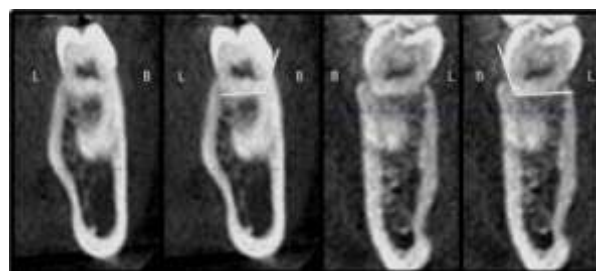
Crown furcation roof angle was measured cross-sectional CB-CT images at selected mandibular first molar teeth. Crown furcation roof angle, is the angle of the line drawn between the furcation entry point and the highest buccal protrusion point on the buccal face of the crown on the image where the furcation roof is the shortest, and the line drawn from the most apical points and the buccal and lingual furcation entry points with the tooth occlusal table in the cross-sectional CB-CT images on cone beam computerized tomography of the chosen first molar teeth. B, Bukkal; L, Lingual.
